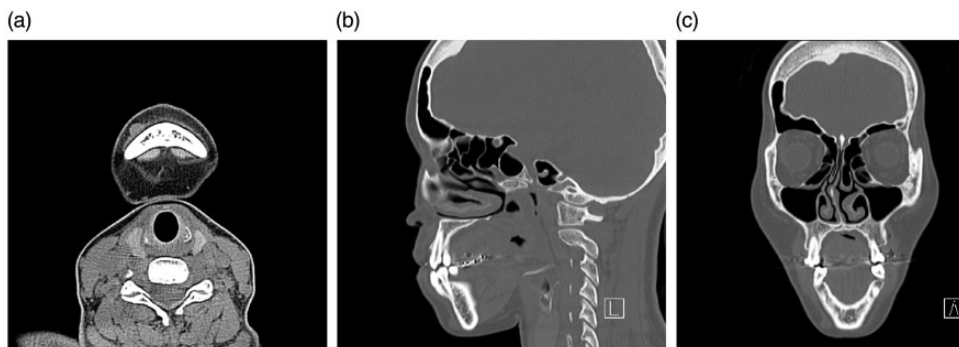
Facial computed tomography revealing a mass measuring 0.8 cm with clear boundaries in the right mental region as shown in the (a) axial, (b) sagittal, and (c) coronal planes.
